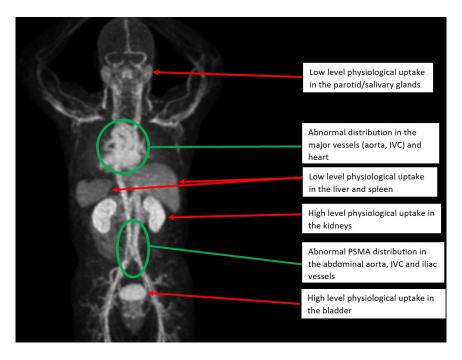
A coronal section of AM's PSMA PET scan, demonstrating grossly abnormal uptake by the vasculature, as well as physiological avidity seen in the salivary glands, kidneys, liver, spleen, small intestine and bladder, and within the prostate, as expected in the context of biopsy confirmed Gleason 4=\$ prostate cancer.
